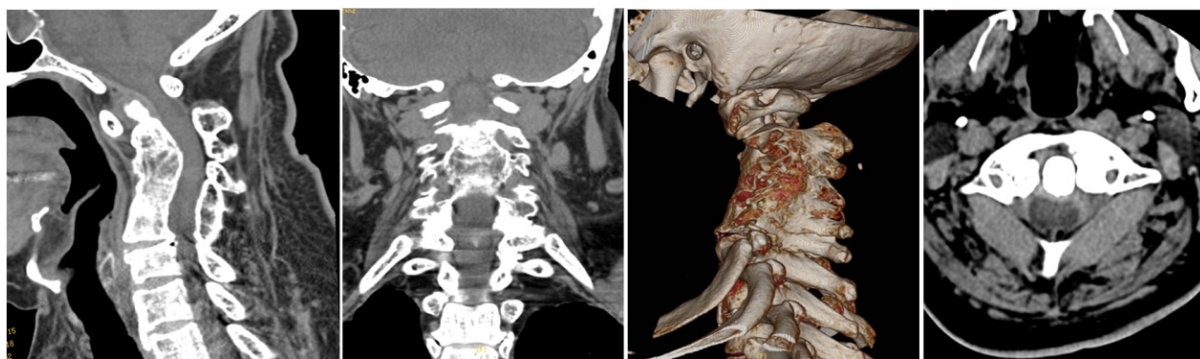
The sagittal and coronal CT images showed that the cervical vertebra was reversed, the C2~C7 vertebral body and its attachments were fused, the horizontal bony spinal canal of C3 vertebral body was narrowed, the anterior space of atlantoaxial joint was widened, and the corresponding segmental bony spinal canal was narrowed. Horizontal position suggests subluxation of atlantoaxial joint
